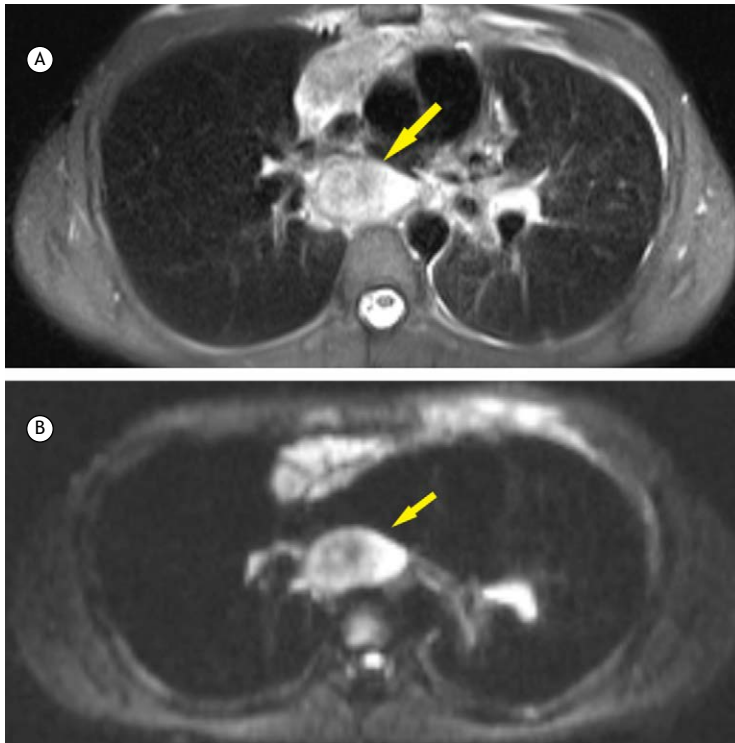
Transverse MRI scans of a 35-year-old man with sarcoidosis. In A, T2-weighted PROPELLER MRI of an enlarged mediastinal lymph node. In B, apparent diffusion coefficient (ADC) map reconstruction of the lymph node. PROPELLER: periodically rotated overlapping parallel lines with enhanced reconstruction. $ADC = 1.74 \times 10^{-3} \text{ mm}^2/\text{s}$.
